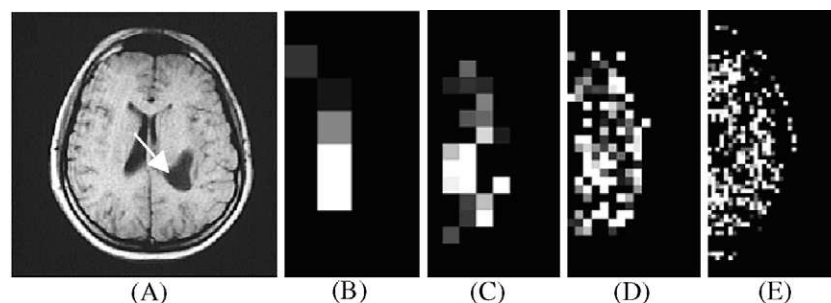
(A) T1 MR image without contrast agent. Also shown are negative FD difference results for (B) Blnkt8, (C) Blnkt16 and (D) Blnkt32 and positive FD difference results for (E) Blnkt64.
